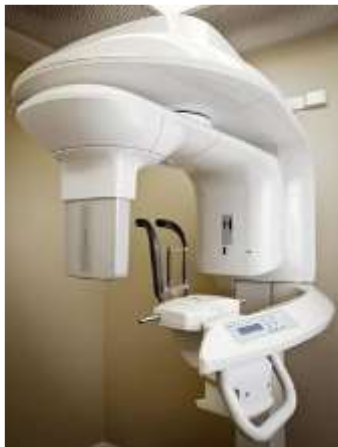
CBCT machine (CS 9000 3D Extraoral Imaging System by carestream)
